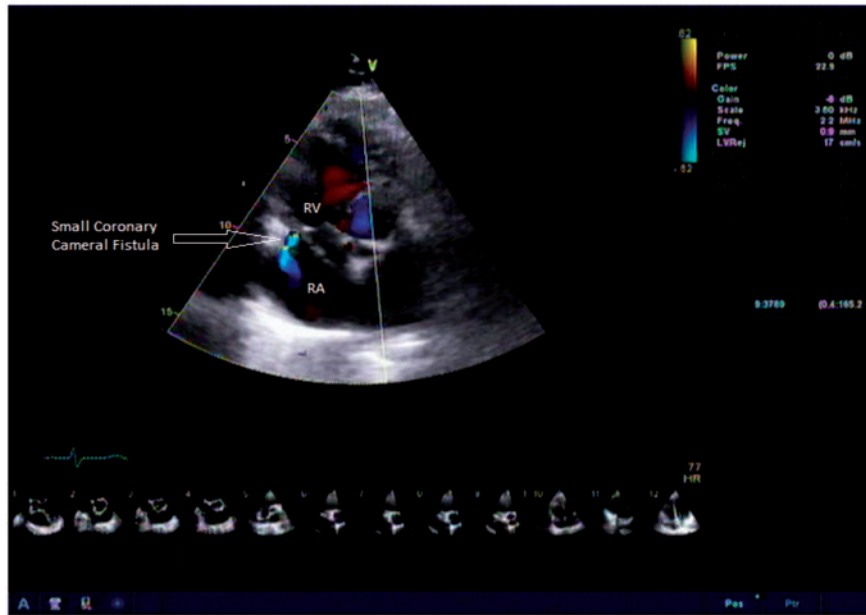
Transthoracic echocardiography showing coronary cameral fistula.
